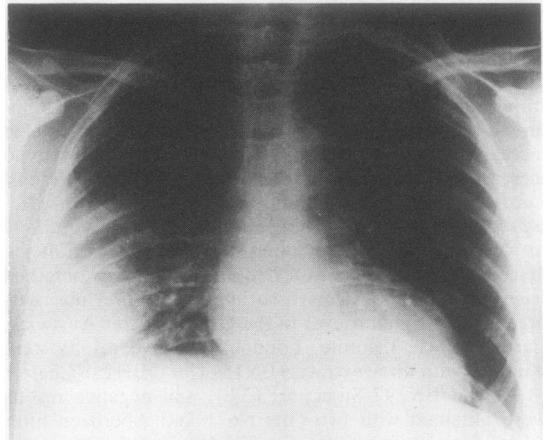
Chest radiographic appearances during the admission to hospital in August 1983.
